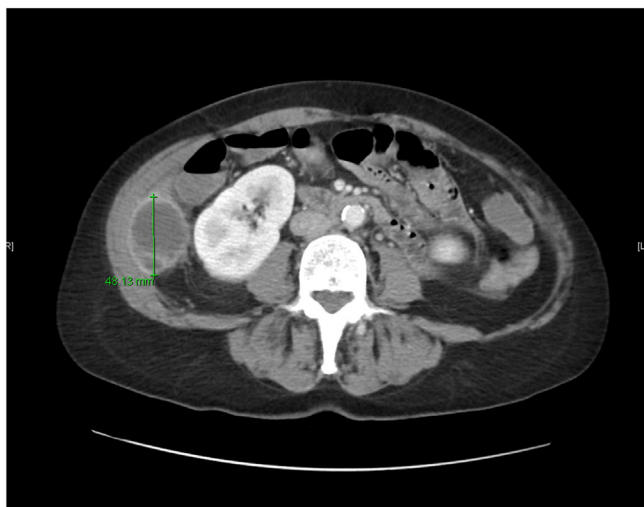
The CT of the abdomen and pelvis with contrast showed a $12.4 \times 4.8 \times 3.6$ cm fluid collection within the right lateral abdominal wall with 2 radiopaque structures resembling gallstones.
